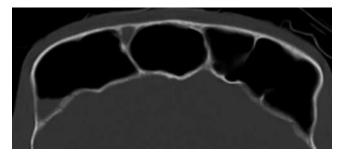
Axial bone window CT scan shows an impressively enlarged frontal sinus in a patient with acromegaly.
